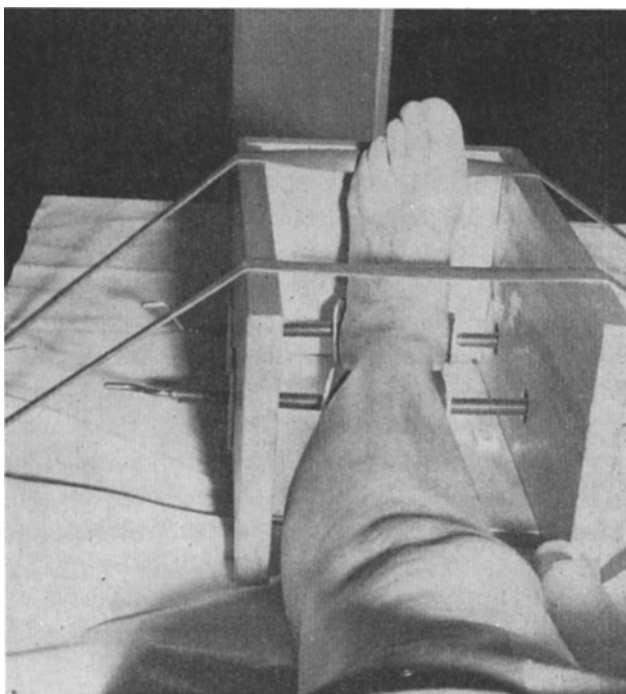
Wooden case lacking front and top parts and furnished with screws, between which the foot was fixed on stress examination. The case was firmly strapped to the X-ray examination table.
